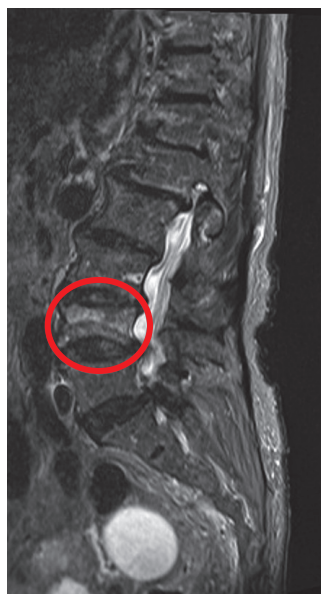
MRI of the 80-year-old Woman Performed 1 Week after Initial Examination
